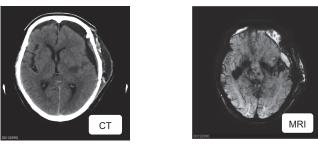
CT and MRI images of basal ganglia hemorrhage a few
